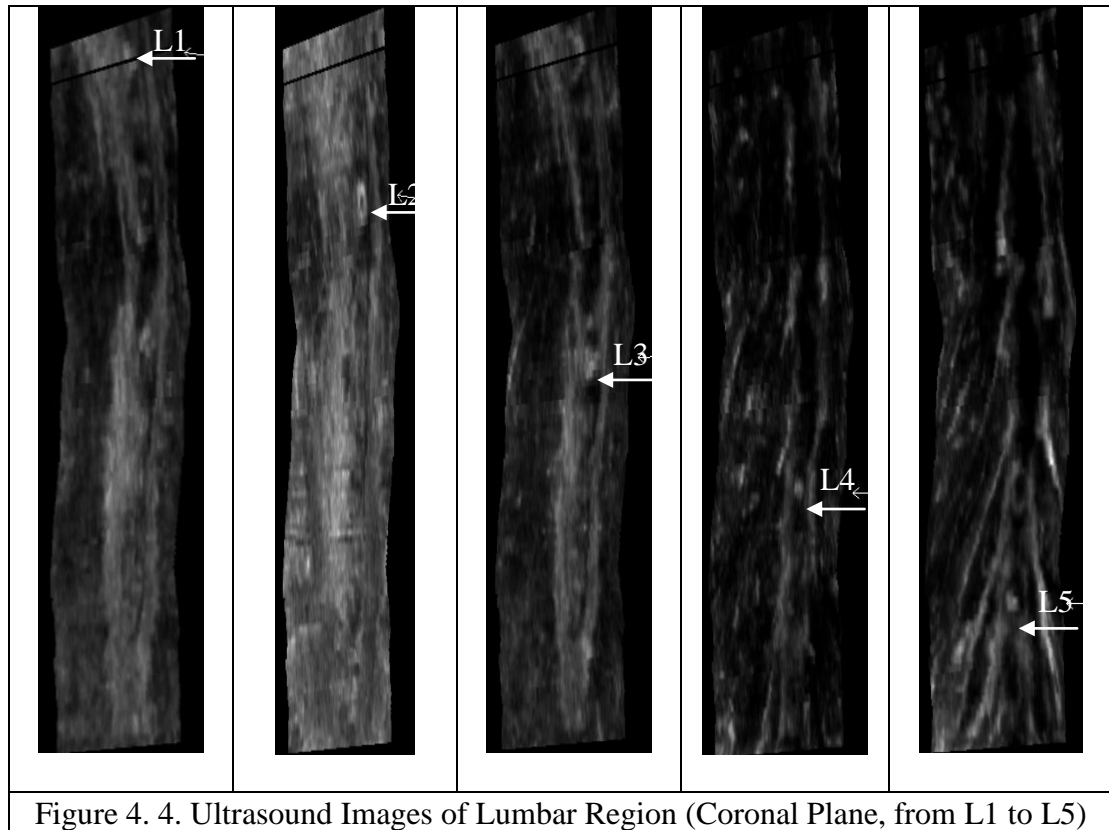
4. Ultrasound Images of Lumbar Region (Coronal Plane, from L1 to L5)
